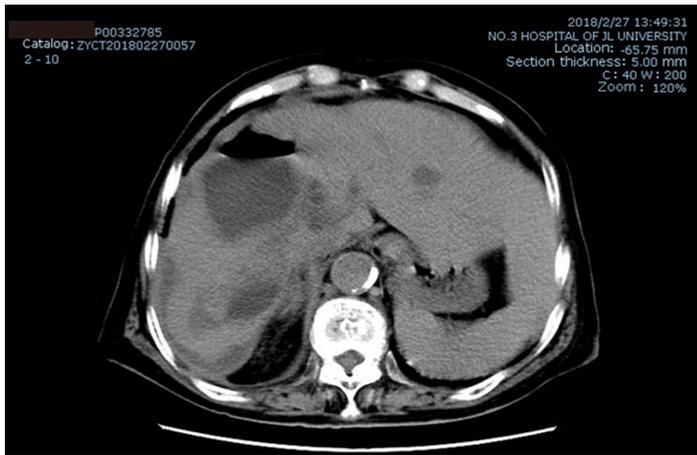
Abdominal computed tomography at 2 mo after treatment.
